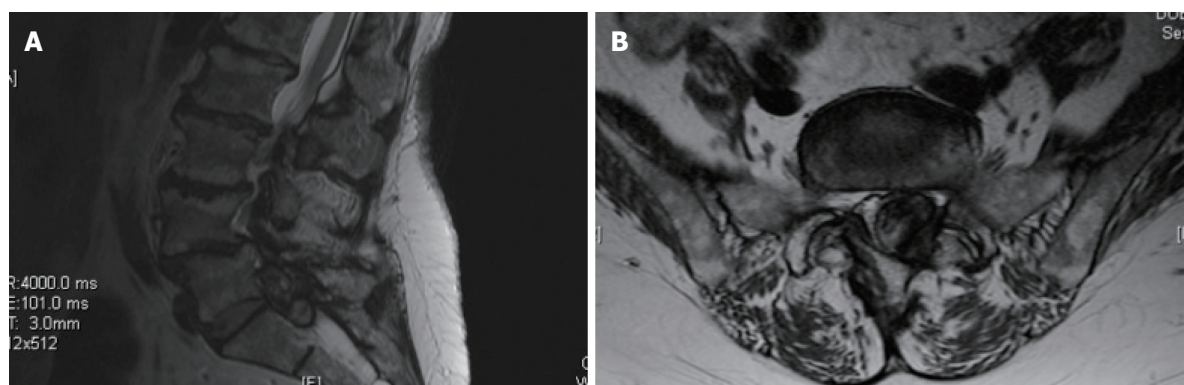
T2 weighted midsagittal (A) and axial (B) magnetic resonance imaging scan showed intraspinal extradural well delineated capsule containing a mixed signal intensity lesion on the left side at L5-S1 causing severe canal stenosis with displacement of the thecal sac to the right side.
